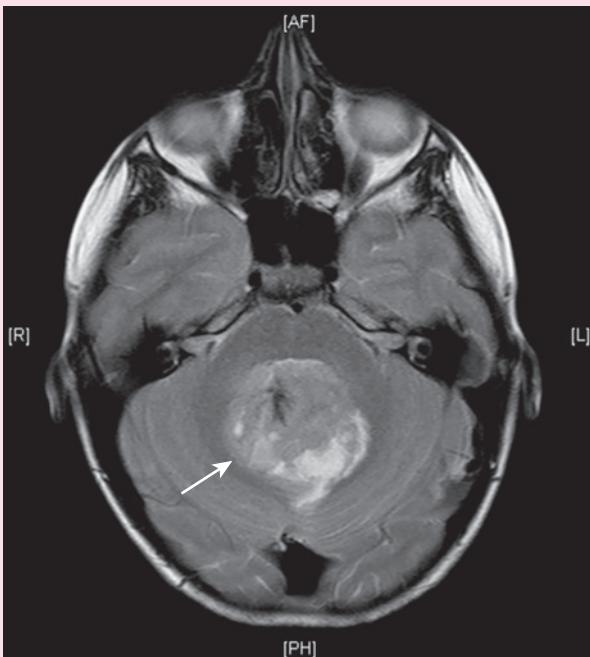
MRI scan showing midline mass in the posterior fossa (cerebellum) typical of a medulloblastoma.
